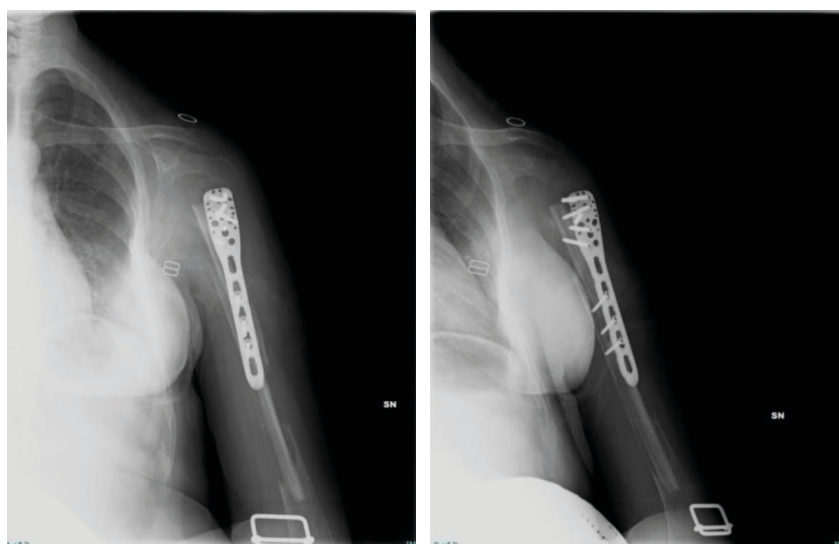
Routine X-rays at 30 days from surgery showed near complete resorption of the left humeral head, without implant mobilizations signs or pain
